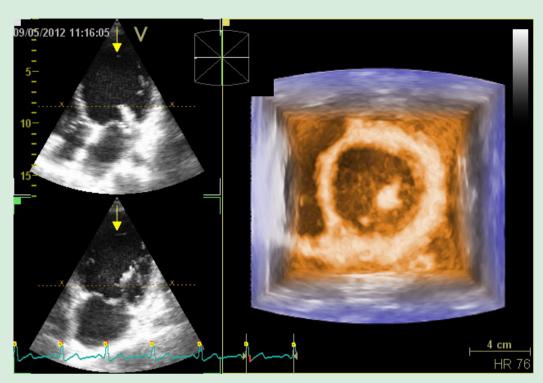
Three-dimensional transthoracic echocardiography - View from the left ventricle to left atrium demonstrating echogenic image compatible with fragment of anterolateral papillary muscle ruptured and still.
